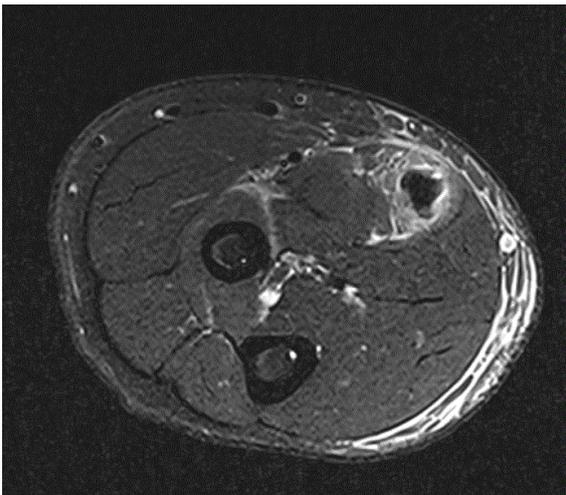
Axial section of T2 MRI right forearm : Like the Fig.1, FCR tendon rupture was seen at proximal origin
